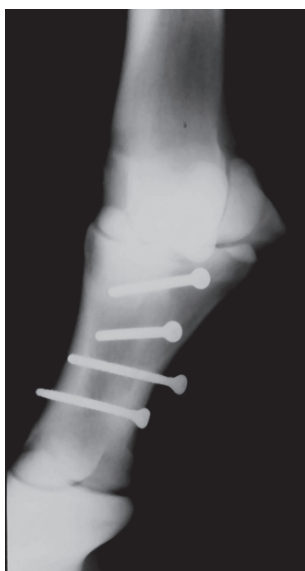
Improper tapping; Inaccurate measurement and poor radiographic control.
